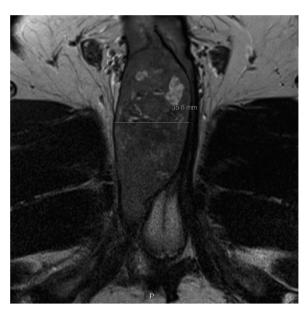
Axial view of pelvis MRI. Axial view of the pelvis on MRI revealed a right corpus cavernosum mass.
